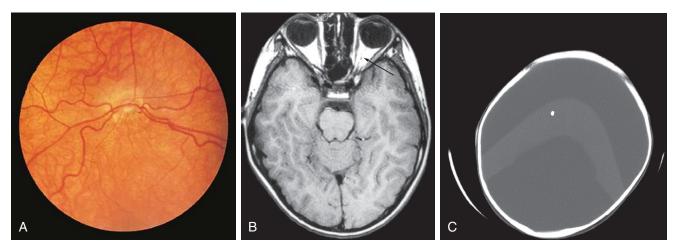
A-C, Congenital abnormalities of the CNS commonly associated with hypothalamic–pituitary dysfunction. A, Pale optic discs noted on funduscopic examination indicative of optic nerve hypoplasia, which can be associated with septo-optic dysplasia. B, Magnetic resonance image showing optic nerve hypoplasia. C, Holoprosencephaly. (A, Courtesy D. Hiles, MD, Pittsburgh, Pa.)
